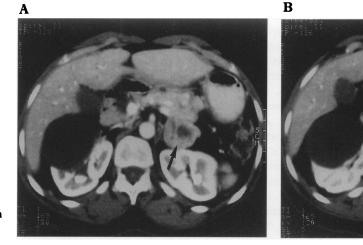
Figure Contrast-enhanced spiral CT scans
